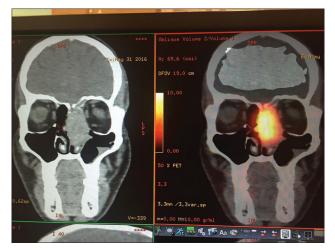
Whole body 68-Gadolinium DOTANOC positron emission tomography-computed tomography fusion scan showing mass in the left nasal cavity with ipsilateral maxillary antrum
